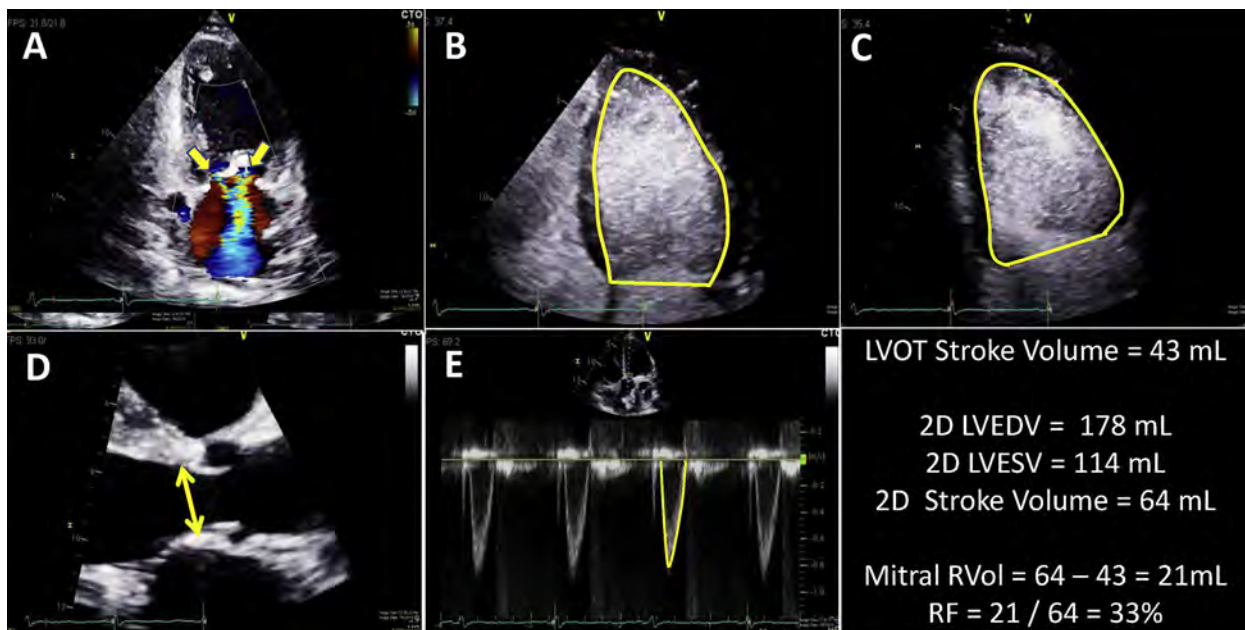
Quantification of mitral regurgitation using a combination of total LV stroke volume (from contrast-enhanced bi-plane LV volume measurements) and LVOT stroke volume (from diameter and velocity measurements). (A) Apical two-chamber view shows two jets of MR and the MitraClip; (B) Apical four-chamber contrast-enhanced image; (C) Apical two-chamber contrast-enhanced image; (D) LVOT diameter measurement, (E) LVOT pulsed-wave Doppler velocity waveform.
